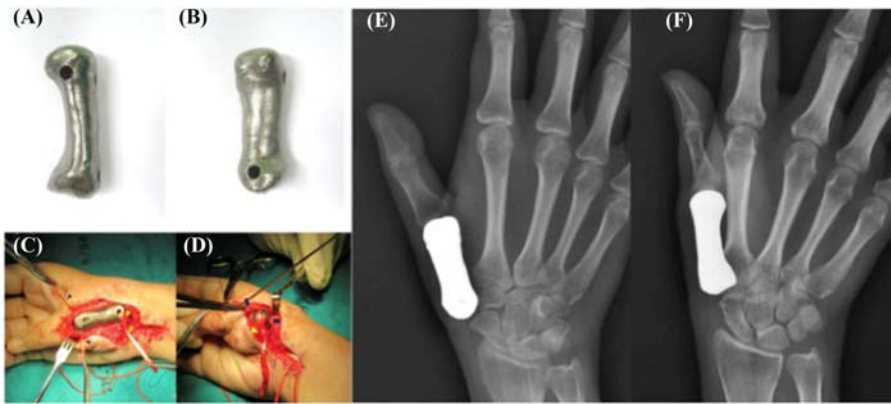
(A) and (B) Three-dimensional printed structures of anterior aspect and volar aspect of prosthesis before implantation; (C) and (D) intraoperative photographs with the 3D printed implant; (E) and (F) radiographs of the patient with the implant.
